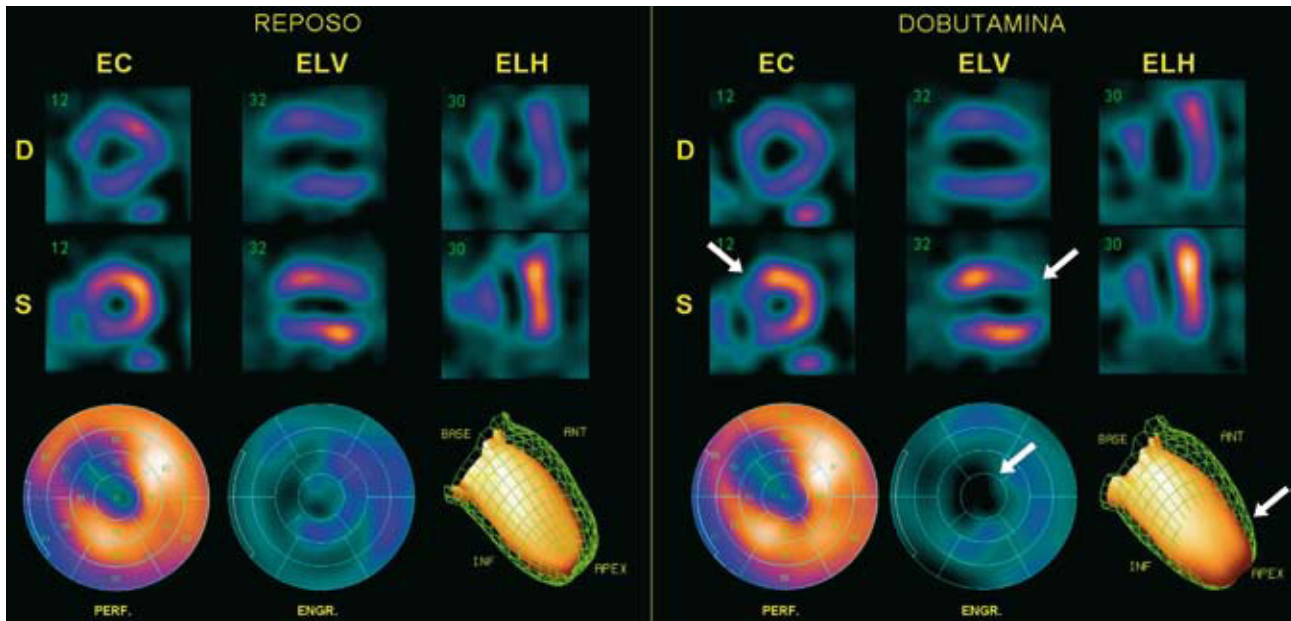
Gated-SPECT myocardial perfusion. Example of negative contractile reserve in the antero-septo-apical region during low-dose dobutamine (LDD) infusion. A decrease can be seen between rest (R) and LDD infusion in thickening and contractility of the antero-apical region (arrows), together with a decreased ejection fraction of 4%. ANT indicates anterior; D, diastole; EC, short axis; ELH, horizontal long axis; ELV, vertical long axis; ENGR, polar map of thickening; INF, inferior; PERF, polar map of perfusion; S, systole.
